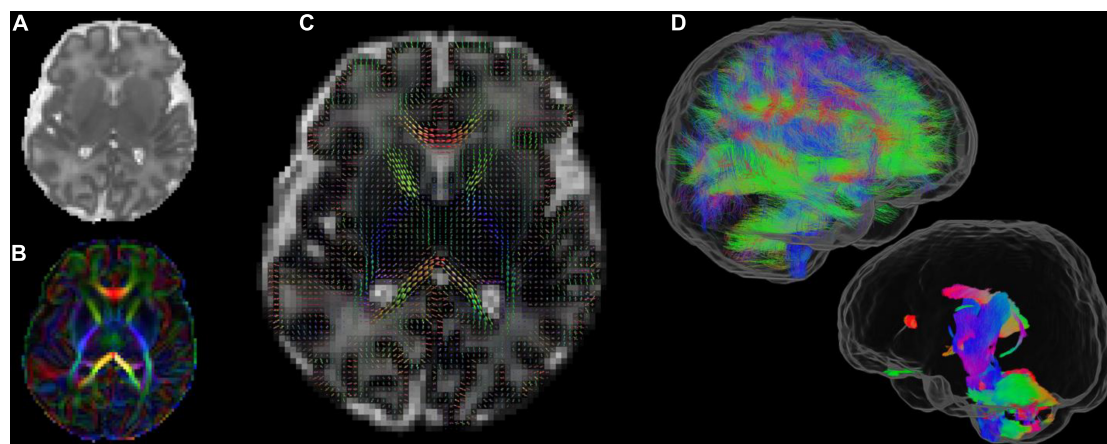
Diffusion MRI metrics in a single subject from the same infant (A) Mean Diffusivity and (B) Color Fractional Anisotropy maps of the Diffusion Tensor Imaging (DTI) model. (C) Tissue Orientation Distribution Function (ODF) of the multi-component analysis in Pietsch et al. (2019). (D) Full brain probabilistic streamline tractography based on the tissue ODF (top image) and based on the mature appearing tissue component (bottom image).
